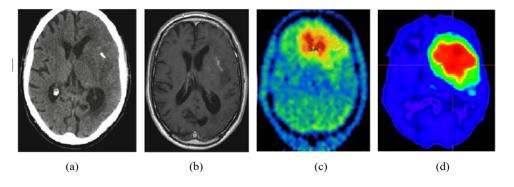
Different types of medical imaging modalities. (a) CT (b) MRI (c) FET and (d) C-MET from WHO high-grade glioma patients [28,29].
